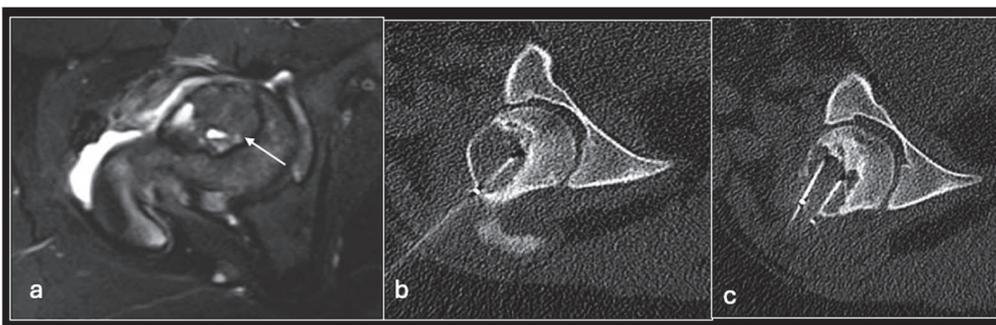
Axial STIR (a) showing femoral head chondroblastoma (arrow) treated with CT-guided radiofrequency ablation with multiple needles (b,c).
